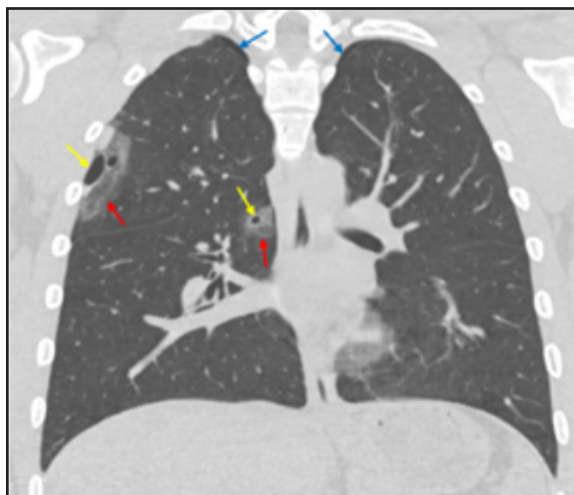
Pulmonary laceration. Coronal unenhanced CT image in a patient after blunt chest trauma demonstrating pulmonary lacerations (yellow arrows) with surrounding ground-glass opacities representing hemorrhage (red arrows). Small biapical pneumothoraces (blue arrows) are also visualized.
